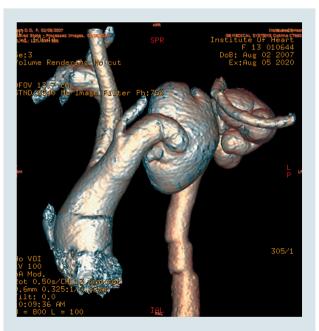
3D reconstructed pre-operative CT angiogram
